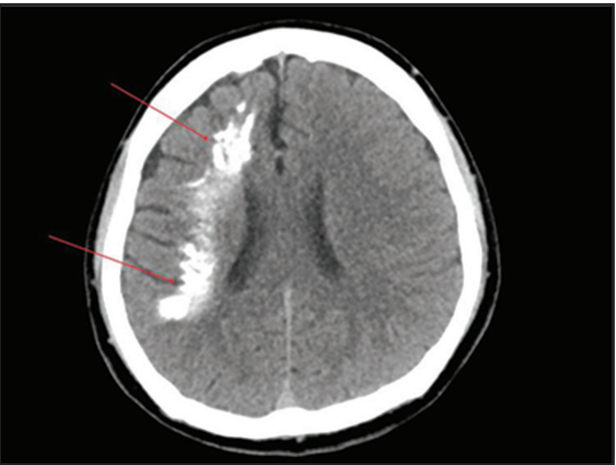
Axial non-contrast CT brain showing dense right parietal cortical-subcortical calcified lesions with surrounding chronic parenchymal changes and adjacent linear calcification extending superiorly (red arrow).
